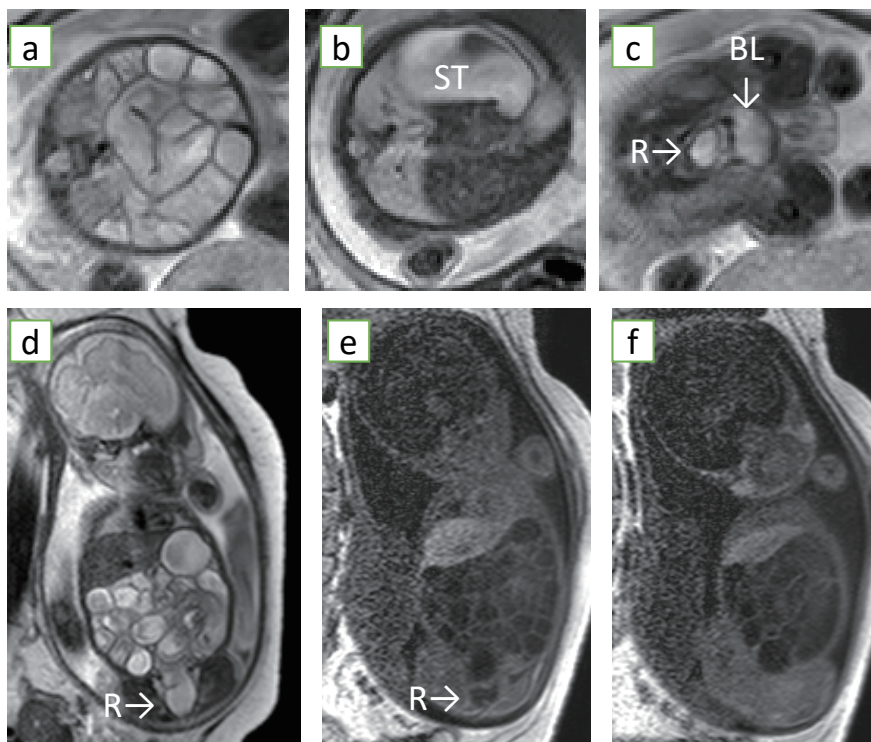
Fetal magnetic resonance imaging at 29 weeks: (a) T2-weighted axial image showing fluid-filled diffuse dilated bowel loops; (b) T2-weighted axial image showing a slightly enlarged stomach (ST); (c) T2-weighted axial image at the fetal pelvis level demonstrating the bladder (BL) and fluid-filled rectum (R); (d) T2-weighted coronal image showing fluid-filled diffuse dilated bowel loops extending to the rectum (R); and (e and f) T1-weighted coronal images showing a lack of the physiological hypersignal, which is usually seen in the distal colon and rectum (R) and is associated with presence of the meconium content, indicating that the bowel is mostly filled with fluid.
